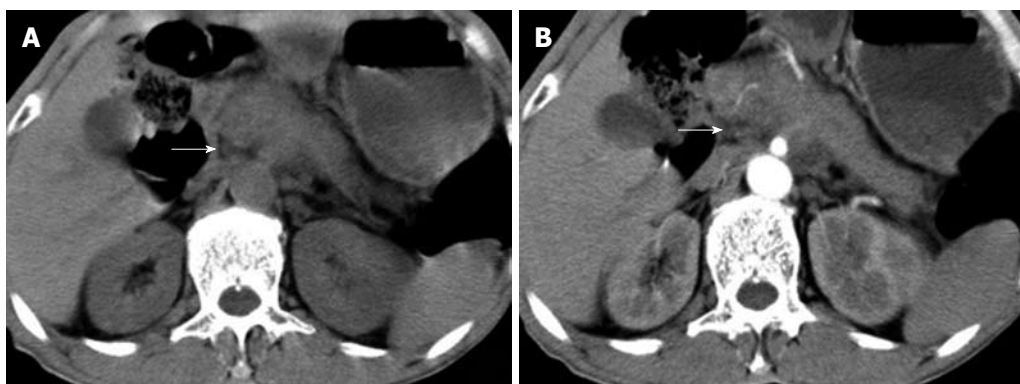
Characteristics of extrapancreatic neural invasion by pancreatic carcinoma on computed tomography image in a 62-year-old male with pancreatic ductal carcinoma. Non-enhanced computed tomography (CT) imaging (A) and contrast-enhanced CT imaging (B) during the arterial dominant phase shows the tumor was located in the head of pancreas and invaded medial to pancreas forming a mass (arrows).
